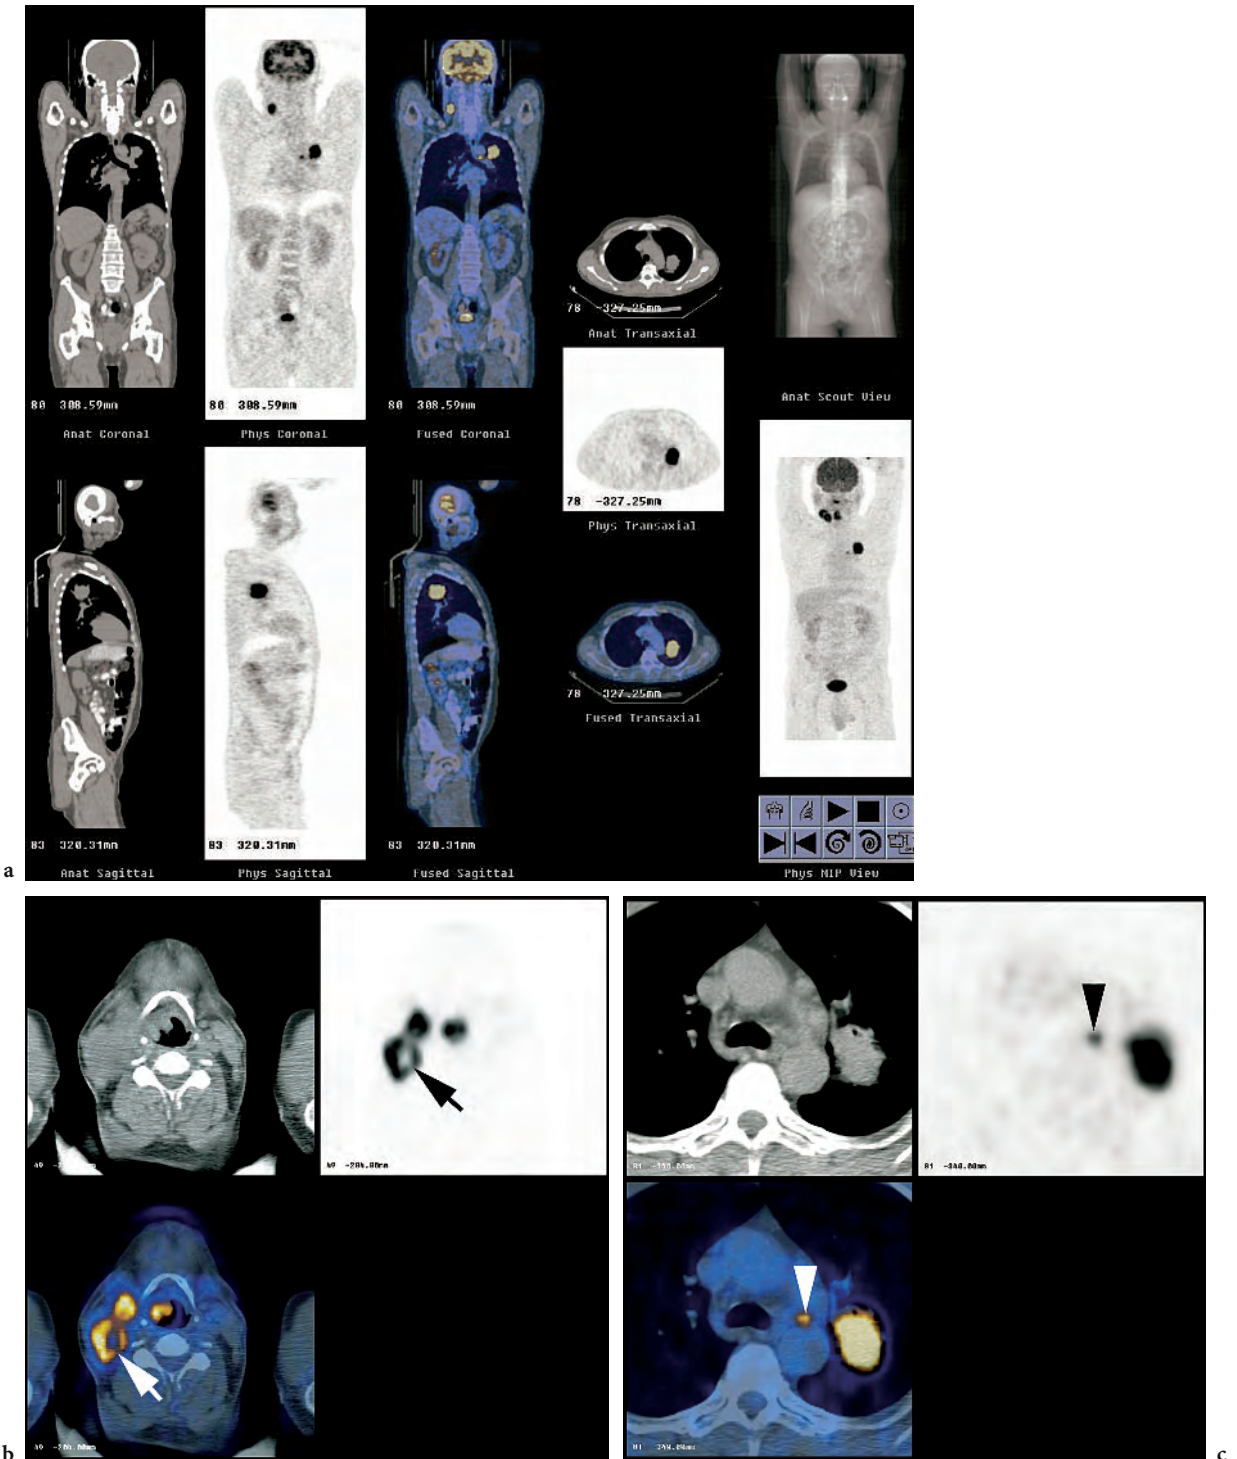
Whole-body PET/CT examination of a 50-year-old male patient who had been suffering hoarseness and a swallowing disorder for 6 weeks. Full screen with maximum intensity projection, CT, PET, and PET/CT scans (a). PET/CT reveals a supraglottic laryngeal cancer with ipsilateral lymph node metastases. There is central necrosis in an enlarged lymph node (b; *white* and *black* arrows). This was a G1 cT2 N2b squamous cell carcinoma. The patient underwent supraglottic partial laryngectomy with radical neck dissection. In the same PET/CT examination a bronchogenic cancer was found with ipsilateral lymph node metastasis in the aortic-pulmonary window (c; *white* and *black* arrowheads). This was a pT2 pN2 squamous cell carcinoma of the left upper lung lobe. The patient underwent resection of the upper lung lobe and mediastinal lymph nodes 3 weeks later. After surgery the patient was scheduled for subsequent combined radiation and chemotherapy
